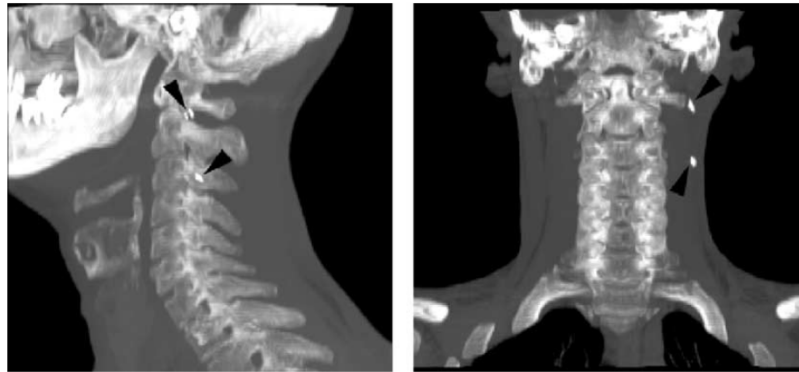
Thick coronal (top) and sagittal (bottom) reconstruction with volume rendering. The examination was performed on a dual-detector spiral CT (Elsint Twin, Haifa, Israel) using a slice thickness of 2.7 mm, an interval reconstruction of 2 mm and a pitch of 0.7. Radio-opaque clips were placed during the neck dissection procedure at the cranial limit of levels II (top arrow head) and V (bottom arrow head). The examination was performed within 3–4 weeks after surgery.
